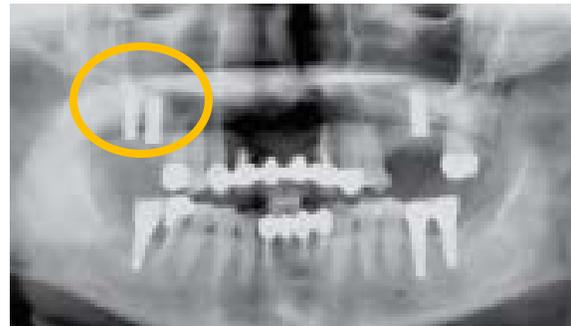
Post-operative radiograph after sinus lift procedure with TruForm+ and placement of multiple dental implants.
